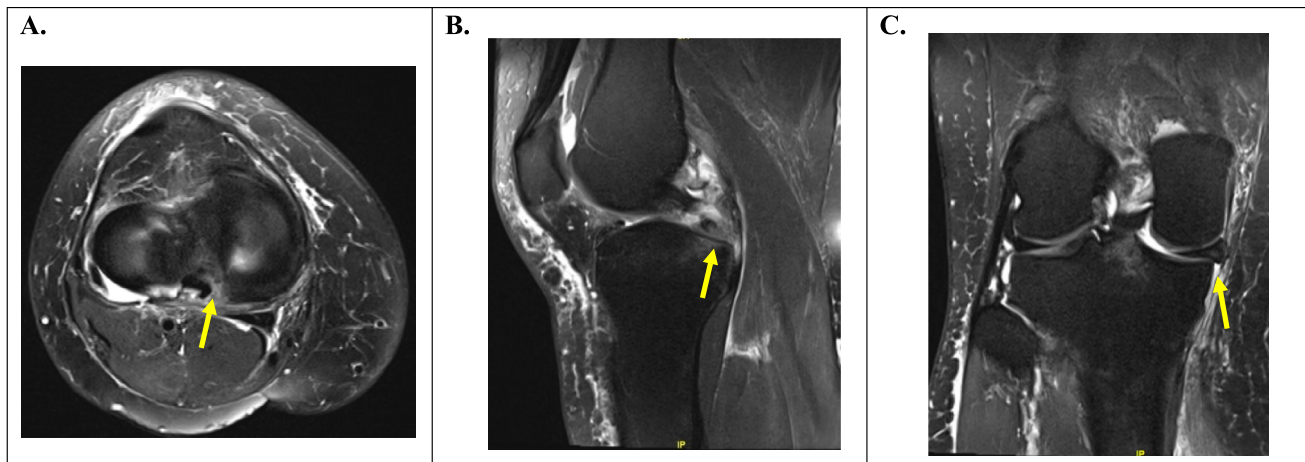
Medial Meniscus Posterior Root Tear with Meniscus Extrusion. STIR MRI sequences demonstrating a medial meniscus posterior root tear (yellow arrow) in the A) Axial sequence demonstrating root detachment with abnormal signal at the attachment site; B)
